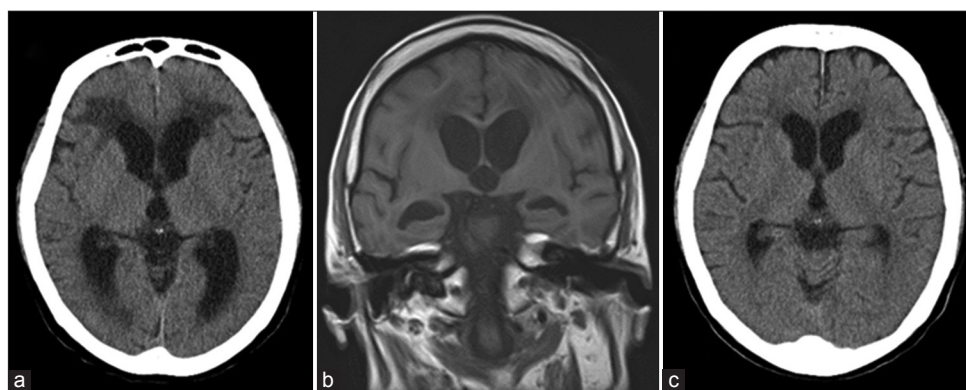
Head computed tomography (CT) scan (a) and head magnetic resonance imaging (MRI; b) at onset showing enlargement of the ventricles. No typical disproportionately enlarged subarachnoid space hydrocephalus findings can be seen. There is no evidence of exacerbation of the hydrocephalus, such as enlargement of the ventricle, or over drainage on the head CT scan (c) when symptoms worsened.
